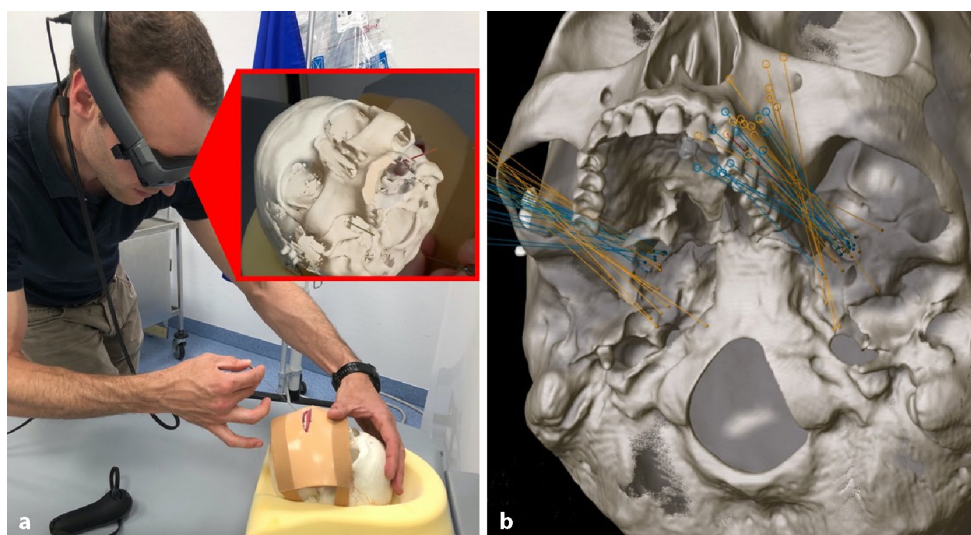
108 a Experimental setup. b Reconstruction of the needle positions ($n=64$) in the postprocedural CT scan, *orange* trajectories carried out conventionally using landmarks, *blue* trajectories using augmented reality (AR) guidance
